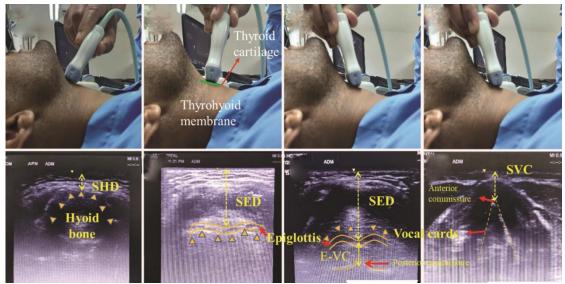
Ultrasonic measurement of Pre E/E-VC Pre-E and E-VC were both measured, and the ratio was computed.
